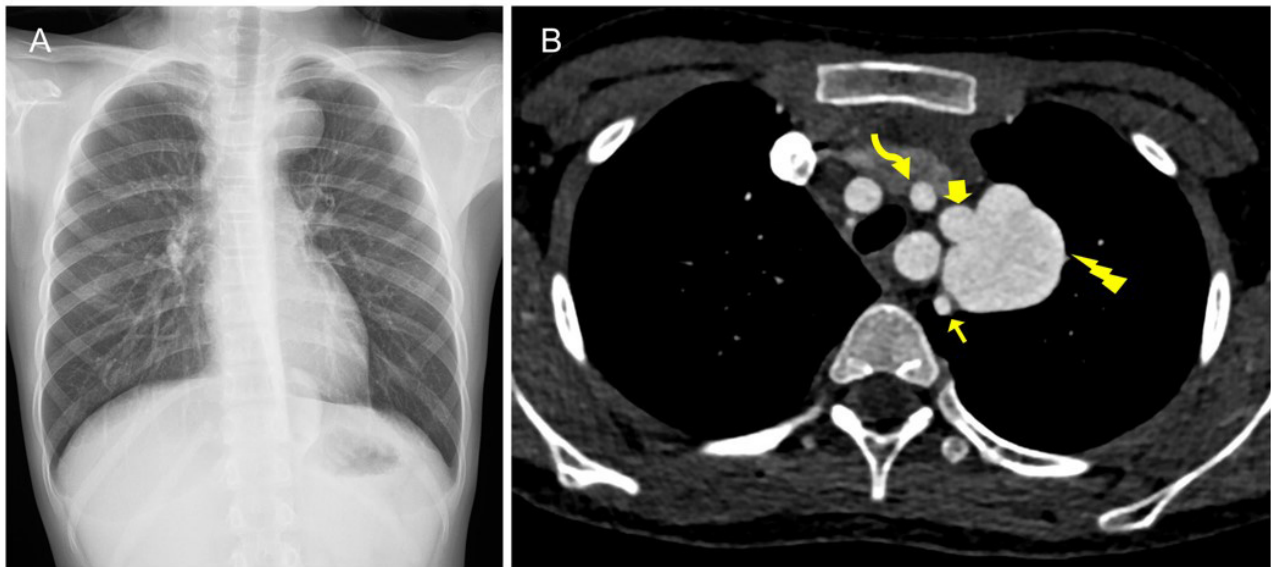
Preoperative chest radiography and transverse CT image. (A) Chest radiograph demonstrating a prominent aortic knob. (B) Transverse CT image showing a saccular aneurysm (lightning symbol), an aberrant left subclavian artery (thin arrow), the aortic arch (thick arrow), and the left common carotid artery (curved arrow). CT, computed tomography.
